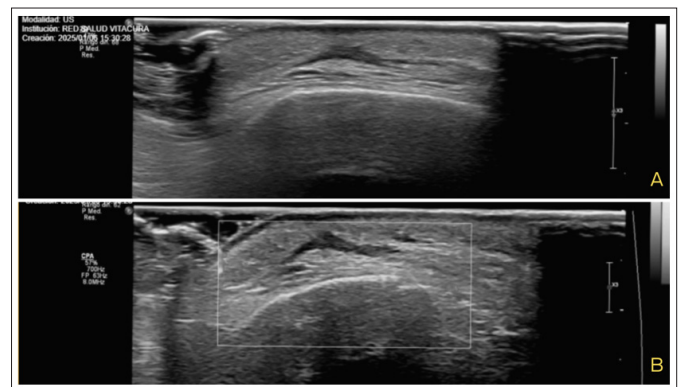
Doppler Ultrasound 3 Months Post-Trauma, Showing Residual Fibrosis In, (A) Right Supraciliary Region, (B) Right Zygomatic Region.
